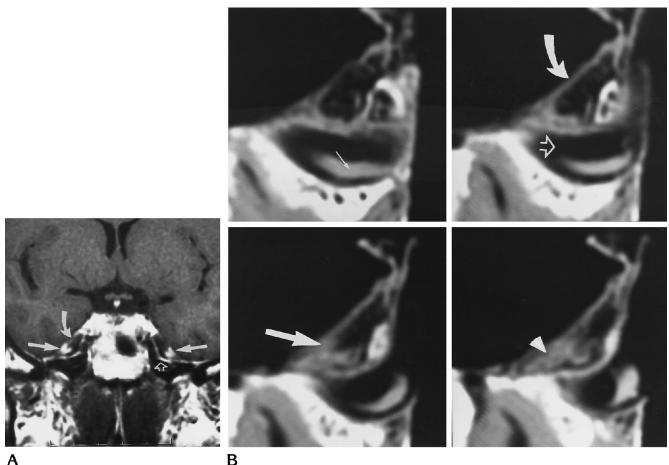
A*, Coronal unenhanced T1weighted MR image through Meckel's caves shows the thin semilunar gasserian ganglion within the left cave (*arrow*).
